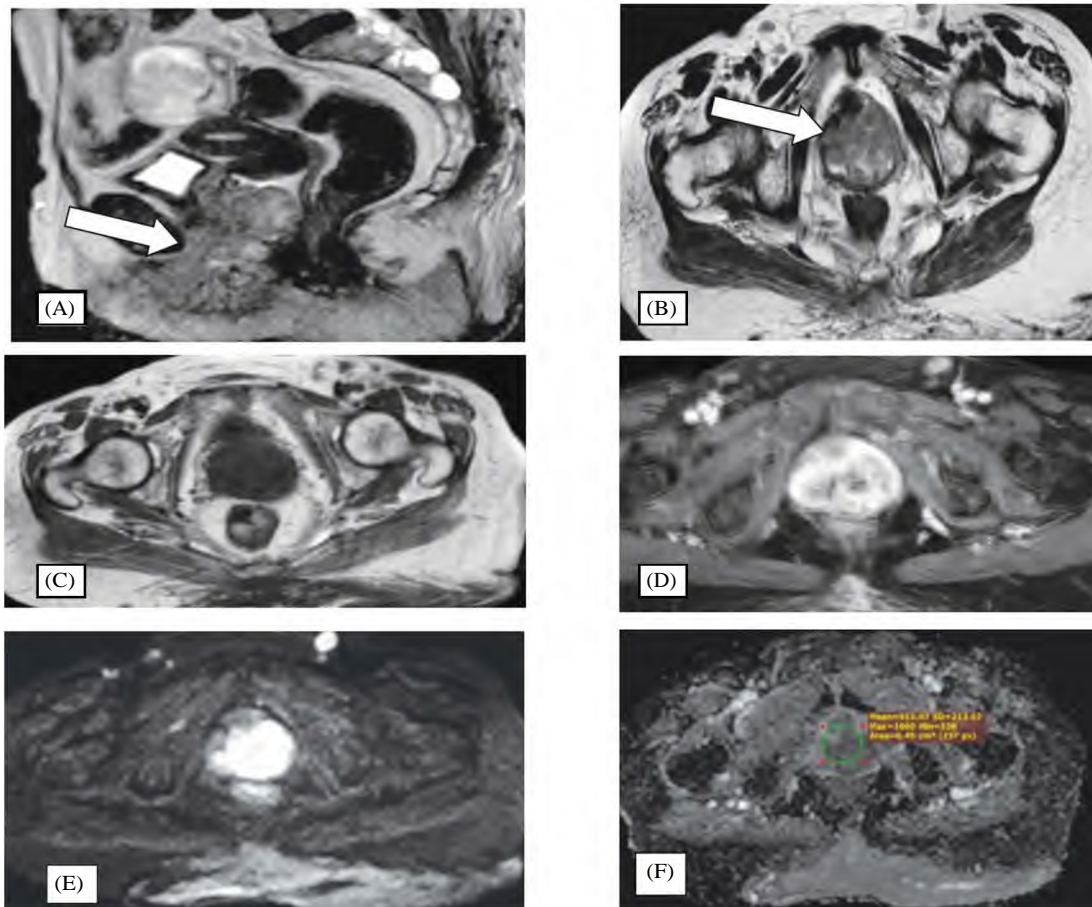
A 68-year-old female presenting with vaginal bleeding. sagittal T2WI. (A) Axial T2WI (B) and axial T1WI (C) Images revealing large infiltrating vaginal lesion eliciting low signal in T1WIs and high heterogeneous signal in T2WIs. The mass is seen infiltrating the lower urethra. Post-contrast (D): It shows heterogeneous enhancement. DWI and ADC image. (E,F) The mass is restricted on DWIs with low ADC. ADC value was $(0.915 \times 10^{-5} \text{ mm}^2/\text{s})$. The lesion was pathologically proven SCC of the vagina.
